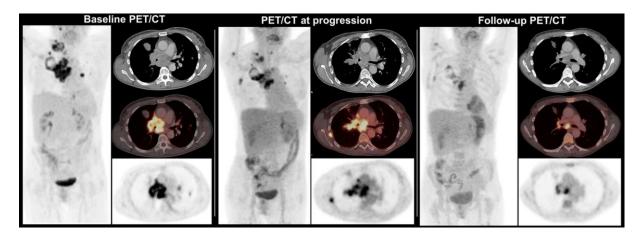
Baseline and follow-up [¹⁸F]FDG PET/CT of a 49-year-old patient with lung cancer cT2b cN3 M0 (TNM 8th edition) with progressive disease (rib metastasis) 2 months after initiation of combined systemic therapy (Figure and caption adapted from Eze et al. (Eze et al. 2021))
